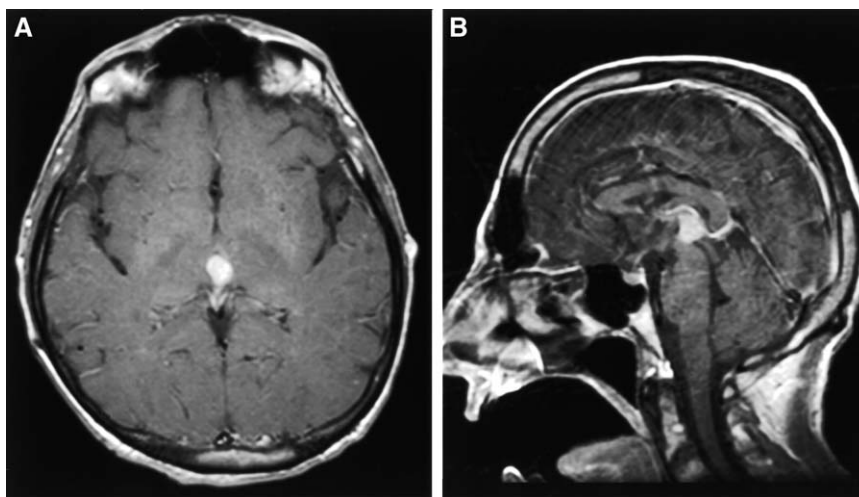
Contrast-enhancing axial (A) and sagittal (B) MRI scans demonstrating a third ventricular tumor in a 42-year-old man with a history of thyroid cancer. The patient initially presented with an intraventricular hemorrhage that was treated with ventricular drainage and a ventriculoperitoneal shunt. The images in this figure were obtained 2 months after the initial presentation when the hemorrhage had resolved. The patient was treated with stereotactic radiosurgery because of the deep location and small size of the lesion.
